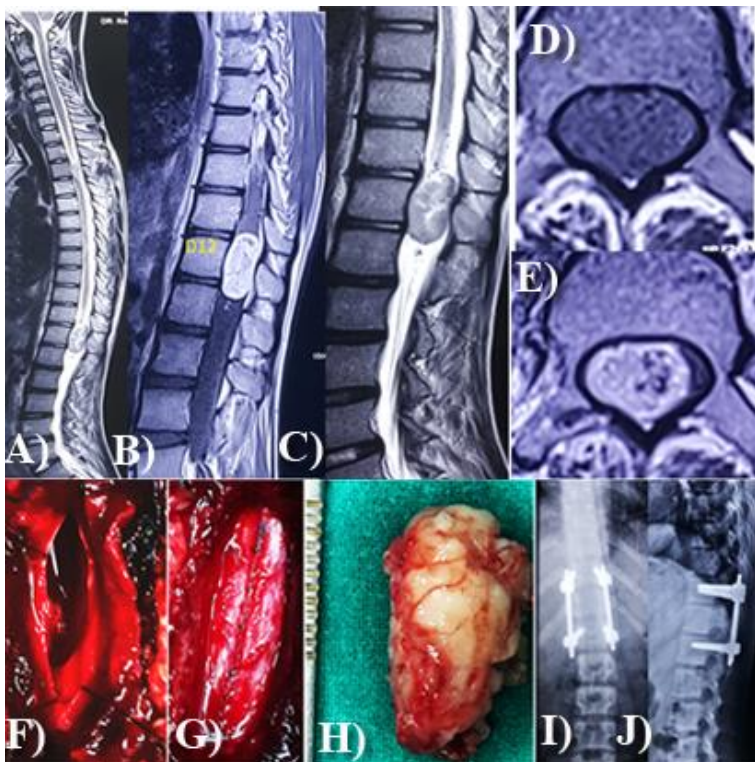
Schwannoma: (A-C) Preoperative sagittal T1, T-2 weighted MRI showing the hetero intense tumor; (D, E) Preoperative axial T1 weighted image and post-contrast T-2 weighted image showing the partially enhanced tumor and severely compressed spinal cord; (F-H) Intraoperative image showing tumor resection; (I, J) post op x-ray after instrumentation.
